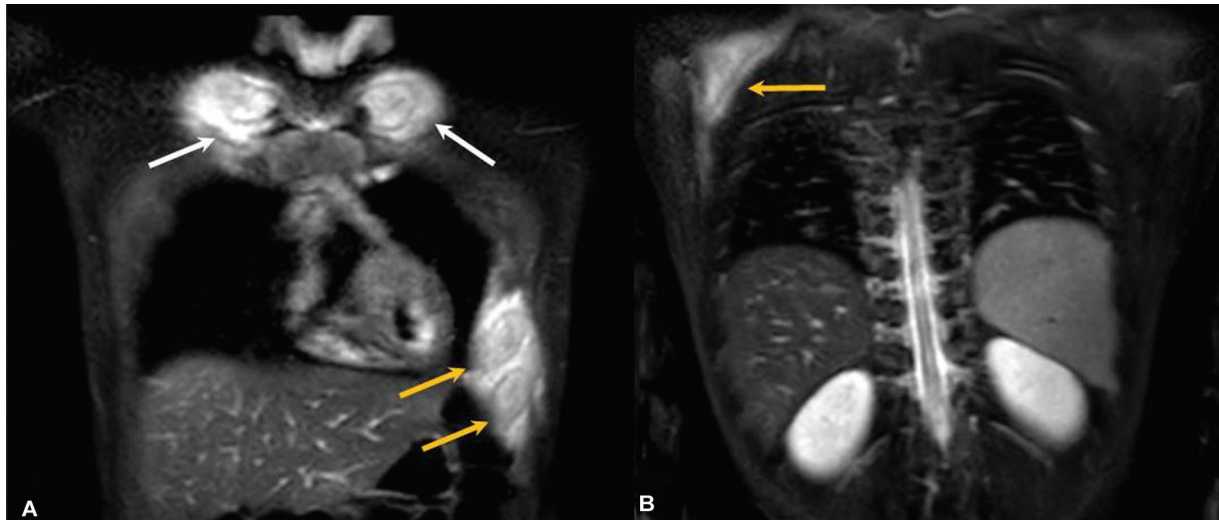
Chronic nonbacterial osteomyelitis (CNO) with flat bone involvement. (A, B) Serial coronal short tau inversion recovery (STIR) whole body magnetic resonance imaging (WBMRI) images at the level of thorax in a 12-year-old with CNO show bony expansion, hyperintense marrow signal with periosteal involvement in left lower ribs (yellow arrow, A), bilateral medial clavicles (white arrows, A), with the latter being considered characteristic for diagnosis of CNO. Similar lesion is also seen in right scapula (yellow arrow, B).
